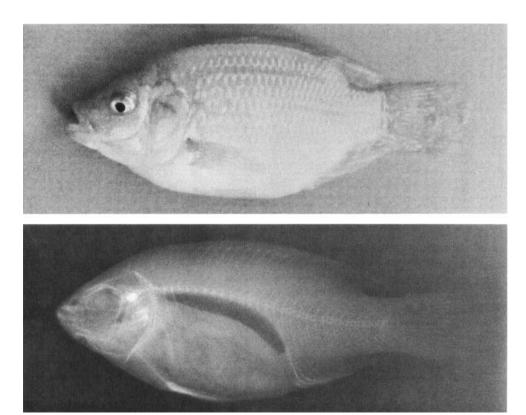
Appearance and radiograph of red hybrid tilapia fed riboflavin-deficient diet for 8 wk showing short body and vertebrae.
